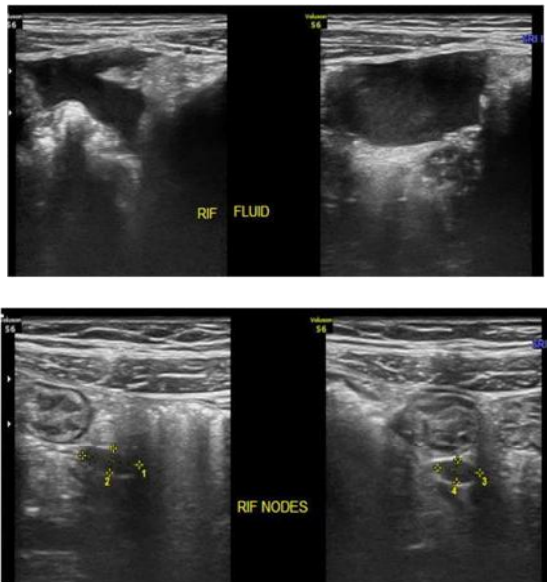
(A, B). 9 year old female child with sonogram of right lower quadrant shows focal free fluid & lymph nodes adjacent to the echogenic bowel loop. The appendix is not seen (Grade 3).
